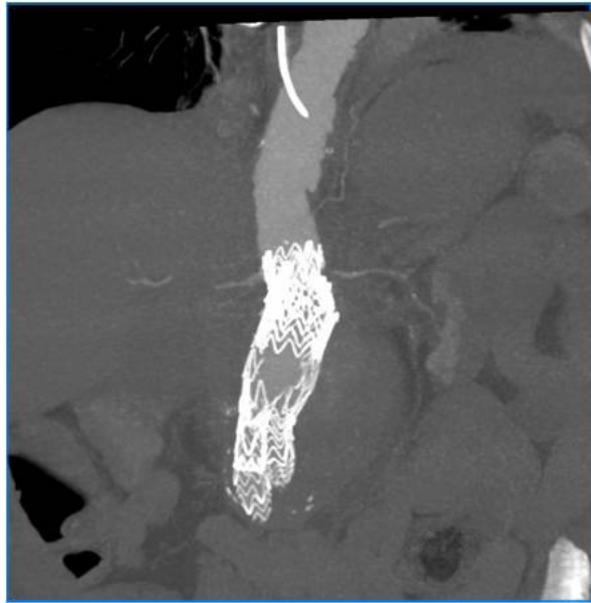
CT angiography after implantation of the aortic cuff in Ia type endoleak.
